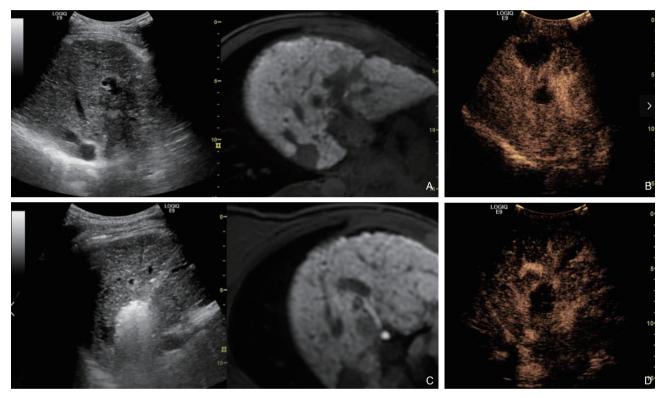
MWA of case 1. (A) MRI-US image fusion showed one tumor located in left liver. Figure (C) MRI-US image fusion showed the other tumor located in right liver adjacent to intrahepatic bile duct, the ablation electrode, the tumor and right bile duct can be clearly displayed on the screen during MWA; (B) and (D) Postoperative CEUS showed complete ablation of the 2 lesions.
